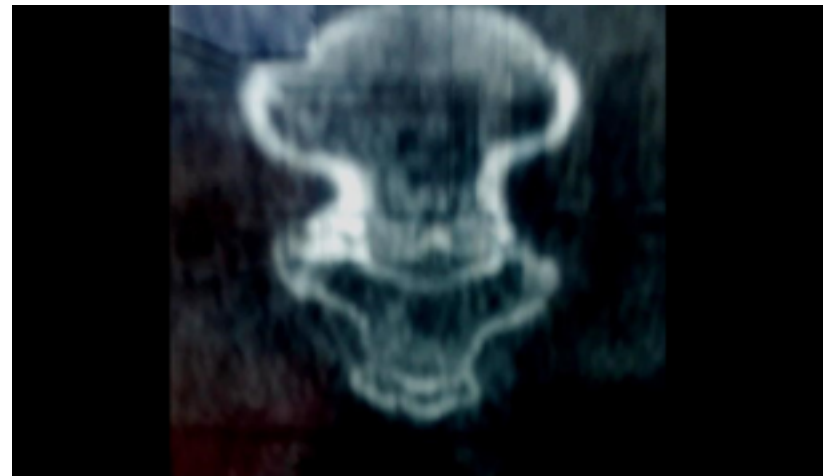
CT in coronal section. Bone disturbances consistent with lateral osteophytes with condensation of the subchondral bone, which may fall within the framework of osteoarthritis.
